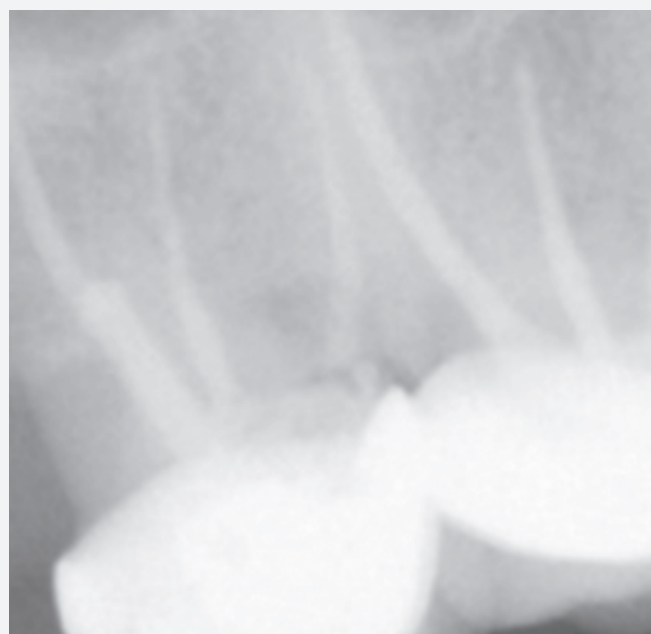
Six months follow-up of panoramic x-ray image.
